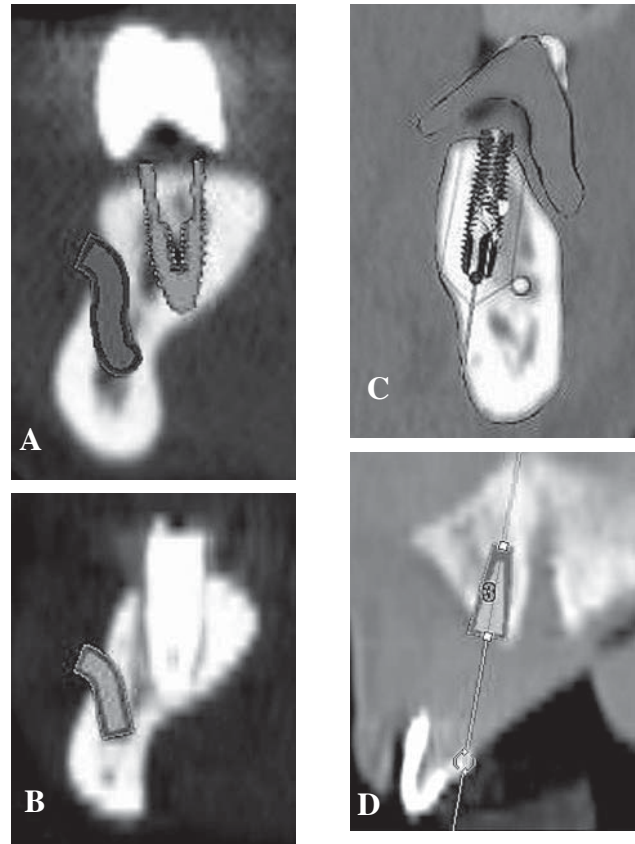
Comparison of A. Virtual treatment plan image for placement of implant #21, and B. CT scan image of actual implant placement. Note the close proximity of the planned implant and the actual implant placement to associated nerves and foramina. C. Implant planned close to the inferior alveolar nerve, D. Implant planned close to incisive nerve canal.
